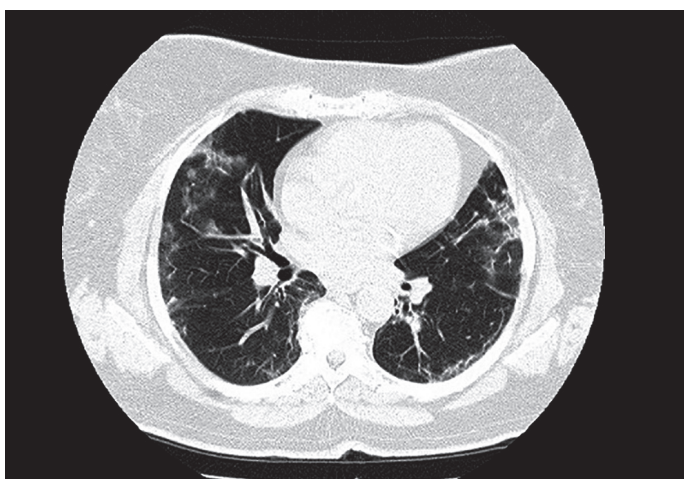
Follow-up chest-CT on day 14.
